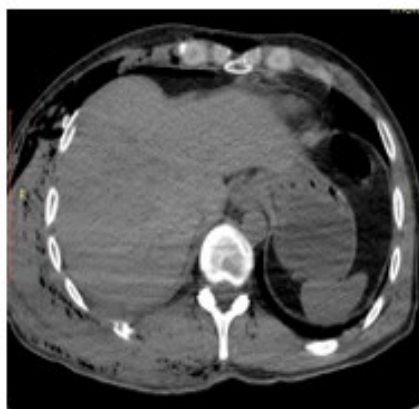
Abdominal CT scan on admission: not revealed liver contusion or/and intraperitoneal fluid.
